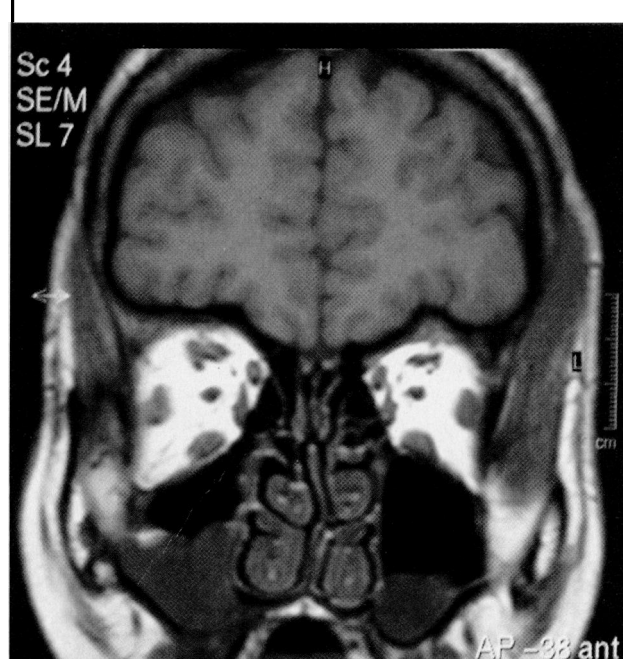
Coronal section of orbital MRI showing enlargement of right and left inferior rectus, left lateral rectus and right oblique muscles.
